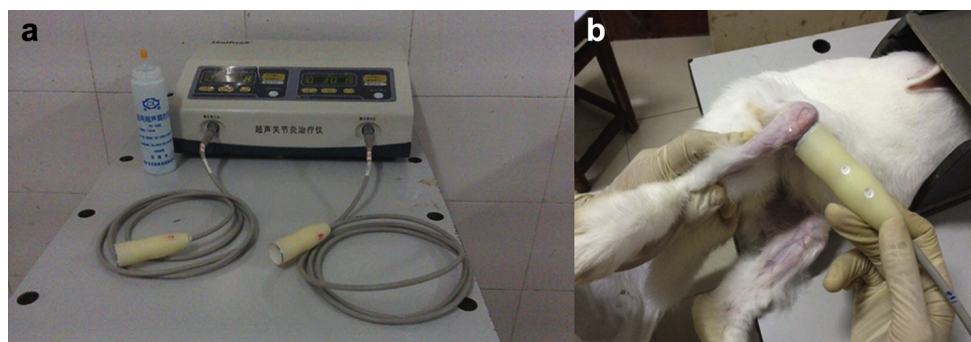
(a) Model CZG200 Ultrasound Therapeutic Device for Arthritis; (b) US probe was close to the skin surface of the medial femoral condyle, and targeted tissue was cartilage of the medial femoral condyle. US = ultrasound.
